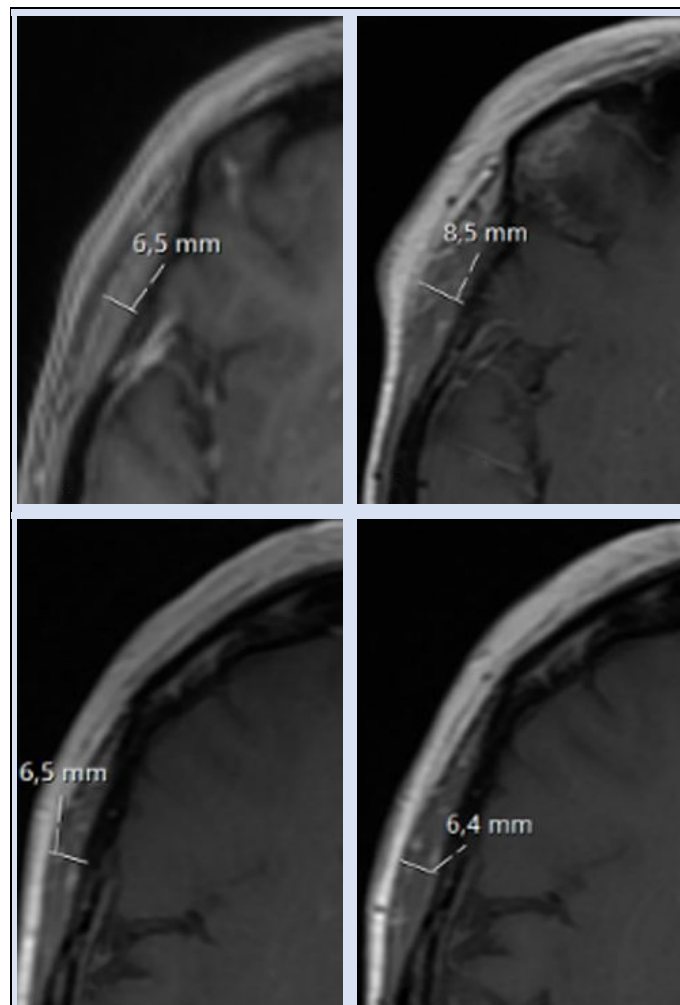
Temporal muscle thickness (TMT) measurement on cranial MRI. A. preoperatively, B. at 1 week postoperatively, C. at 3 months postoperatively, D. at 6 months postoperatively
